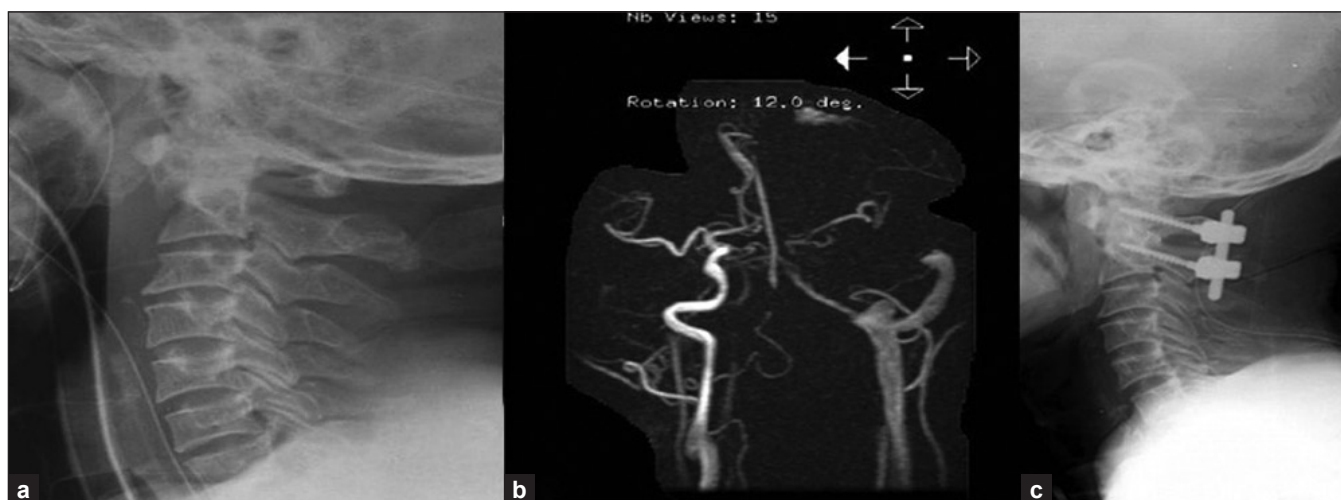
(a) X-ray cervical spine (lateral view) showing atlanto-axial subluxation; (b) MR angiogram showing vertebral artery occlusion on the left side; (c) 2-year follow-up X-ray showing good reduction with unilateral fixation and adequate fusion of C1 and C2
